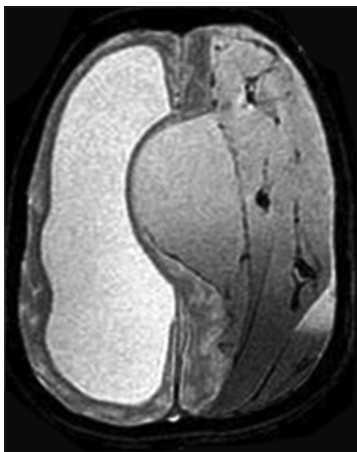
Preoperative T2 weighted MRI showing multiple septations in chronic subdural hematoma
